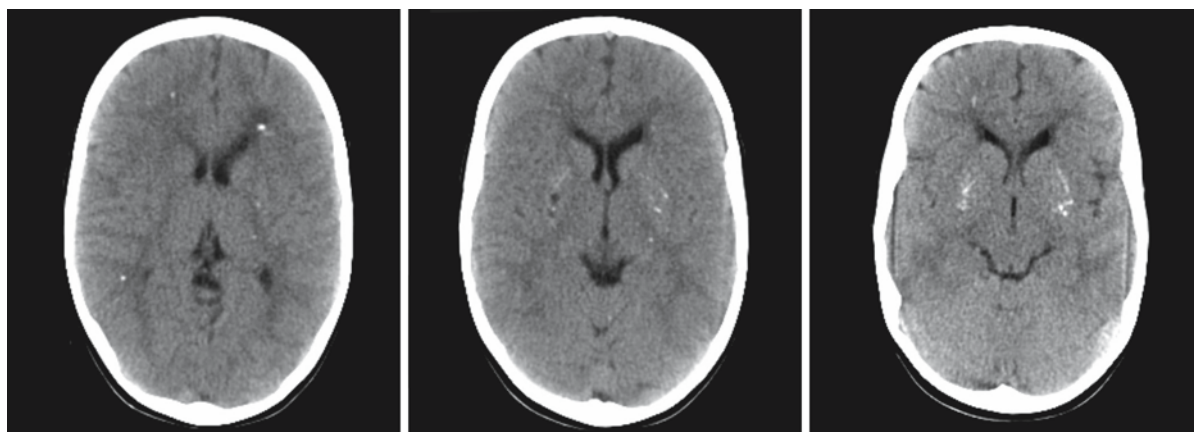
CT scan of the affected brother of the patient shown in Figs. 66.1 and 66.2. He is 7 years old. He has a much milder phenotype and can walk with support. Note the subtle
